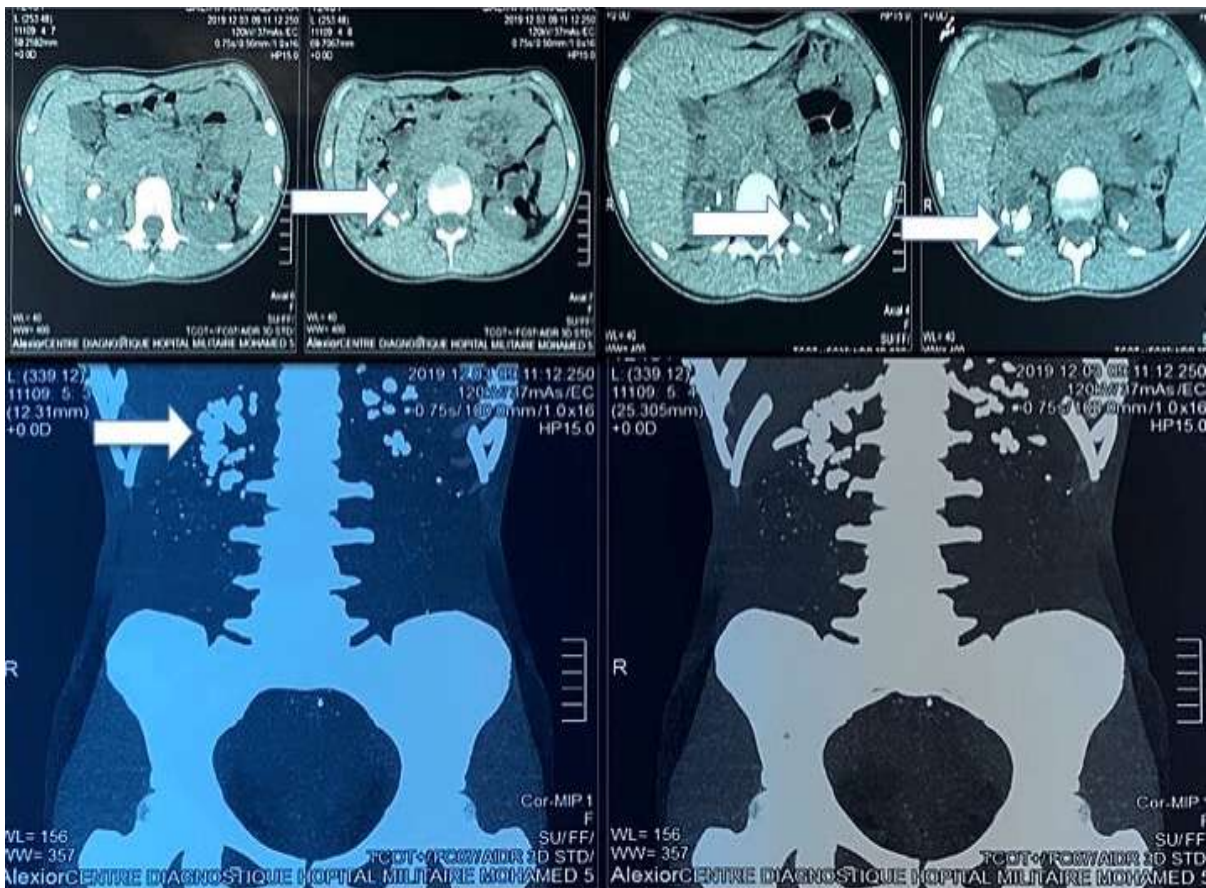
CT-SCAN showing kidney stones occupying all excretory cavities.
